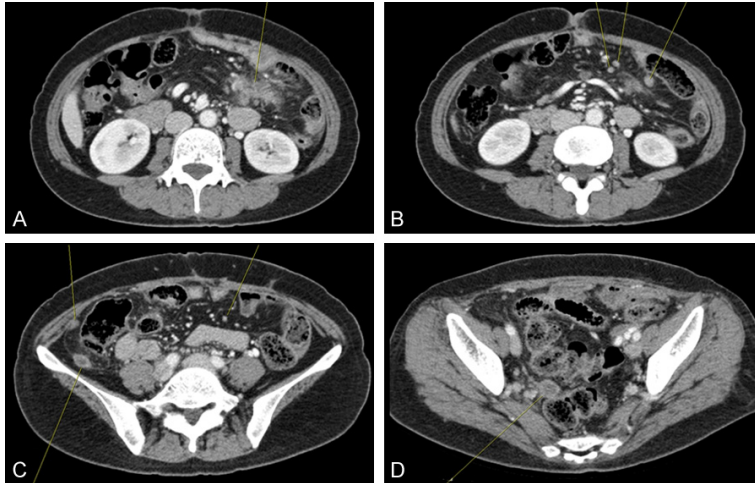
Abdomen pelvis computed tomography findings (A-D) showed multiple enhancing nodules in the small bowel mesentery and the right peritoneal wall with a minimal amount of ascites and a suspicious rim-enhancing nodular lesion in the right salpingo-oophorectomy site. That was suggestive of peritoneal metastasis.
